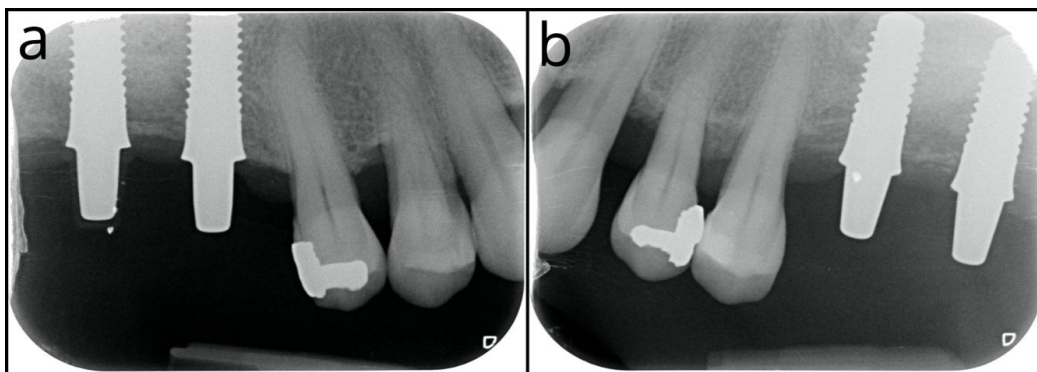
Radiographs performed immediately after implant placement. a. 1.6 and 1.7 positions. b. 2.6 and 2.7 positions.
